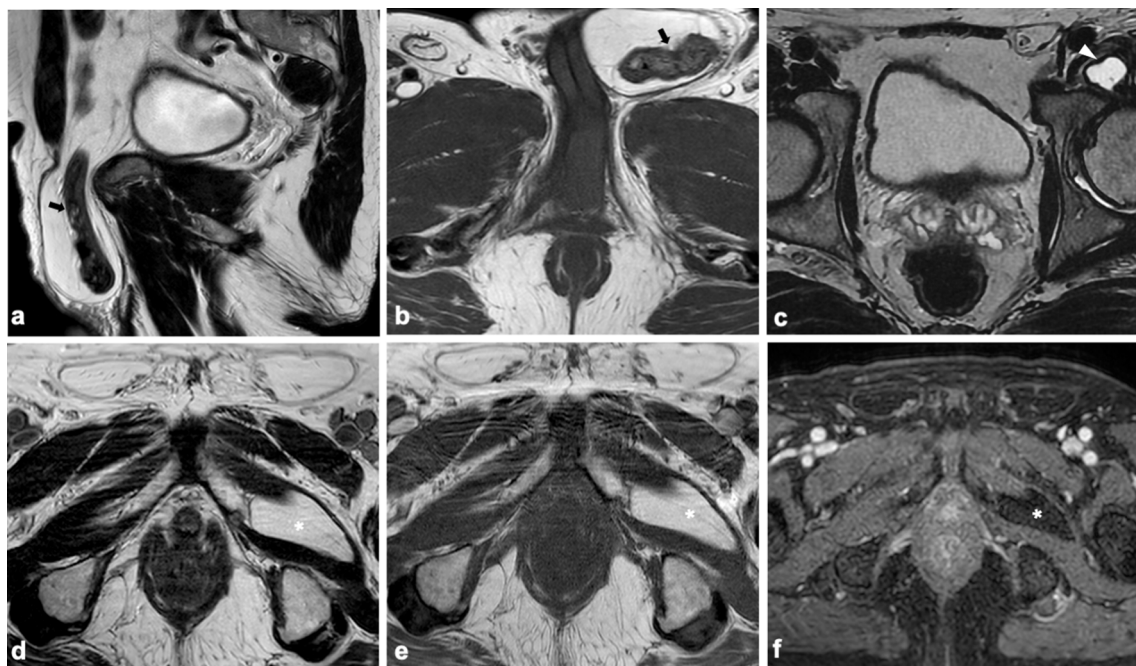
Sagittal T2w (a) and axial T1w (b) images show left inguinal hernia containing fat and a small bowel loop (black arrows). Axial T2w image (c) shows a left fluid-filled distended iliopsoas bursa (white arrowhead), in keeping with iliopsoas bursitis. At the level of the left great adductor, a large regular and homogeneous formation (white asterisks), appearing hyperintense on both T2w (d) and T1w (e) images without signs of contrast-enhancement on post-contrast fat-sat T1w (f) image, is shown, suggestive of intramuscular lipoma. T2w T2-weighted, T1w T1-weighted.
